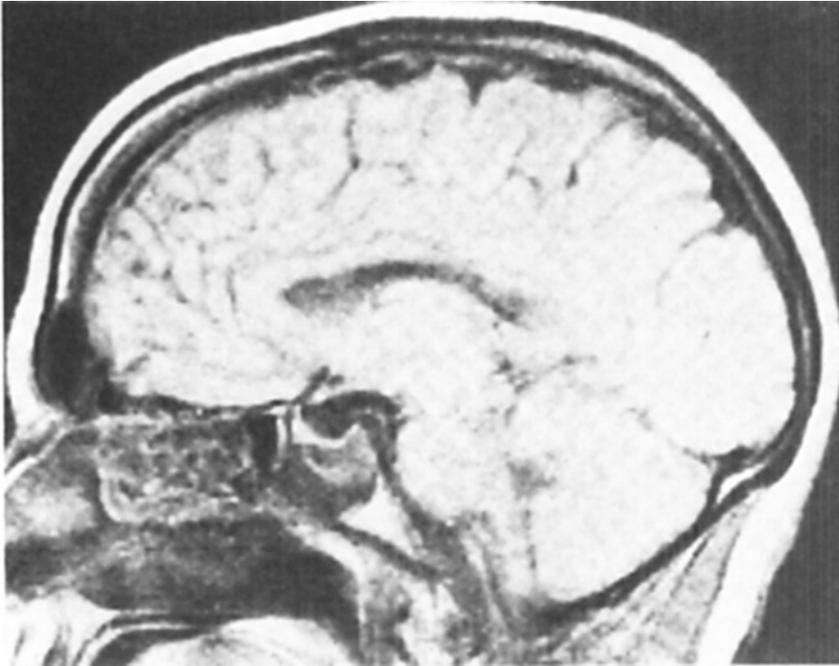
Midsagittal MR image demonstrating the reduced size of the tumour immediately after the cyst puncture. Subtraction image.
